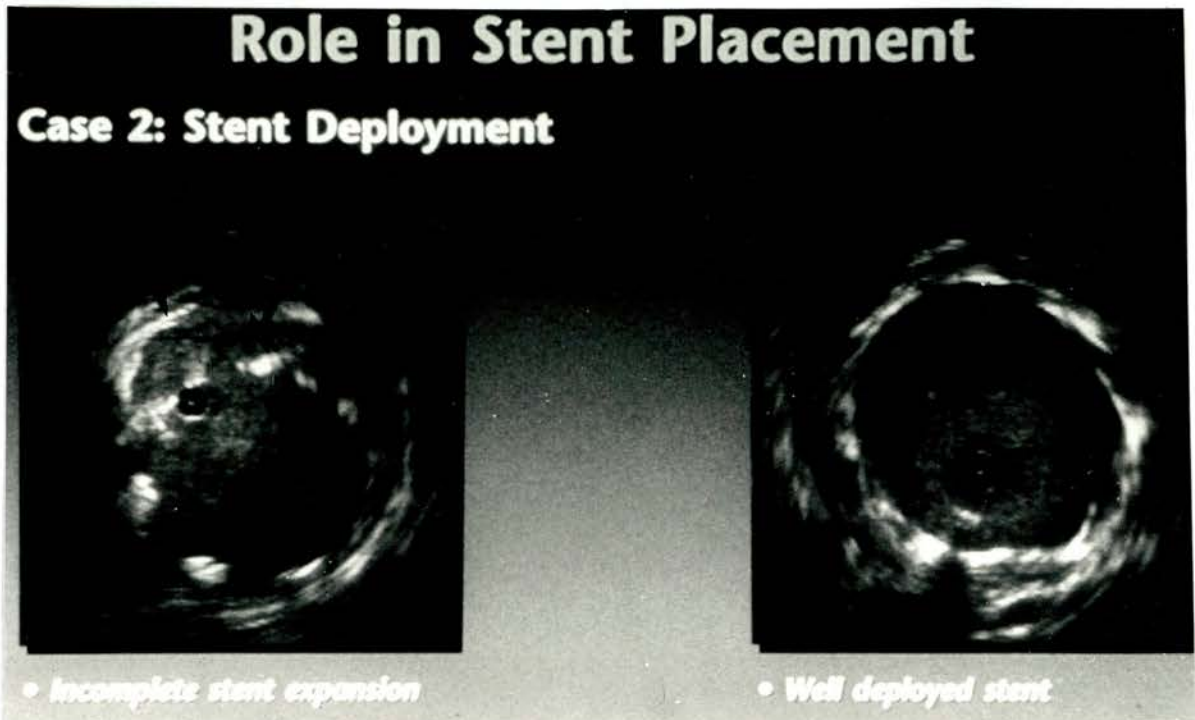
Intravascular ultrasound of stent deployment. The image on the left shows incomplete expansion of the stent (vessel wall - straight arrow, border of stent - curved arrow). Following further angioplasty, intravascular ultrasound confirms full expansion of the stent.
